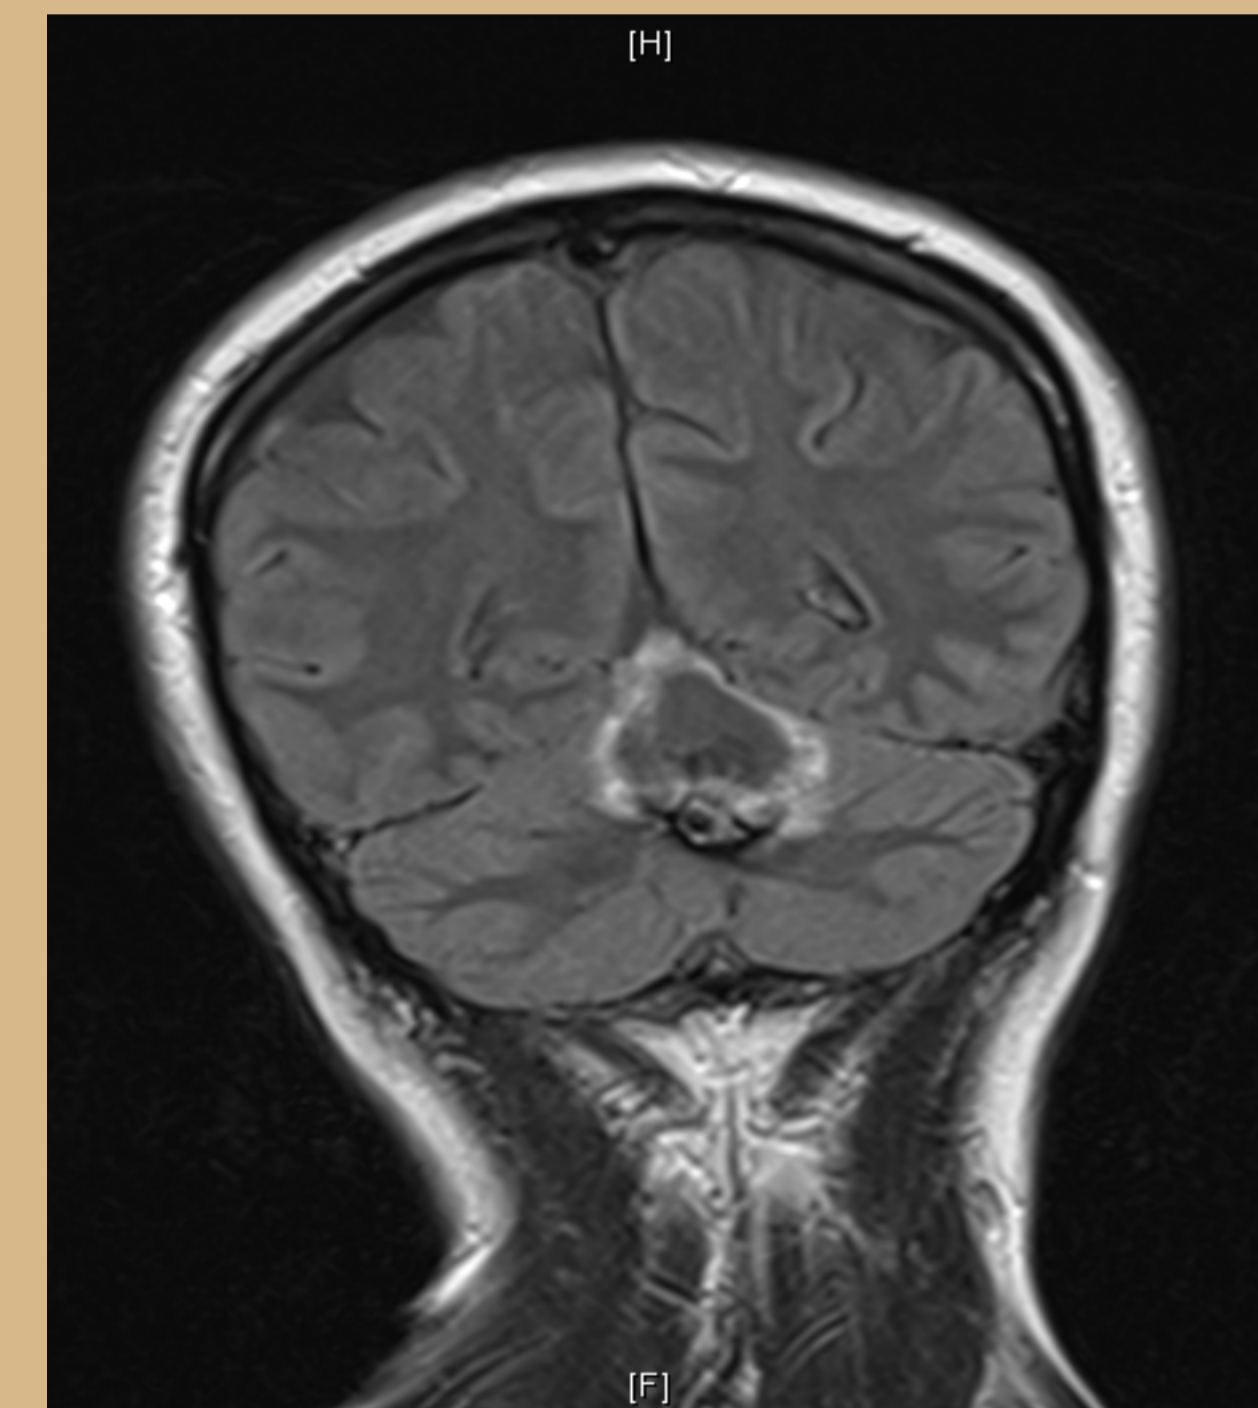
T2 FLAIR coronal
